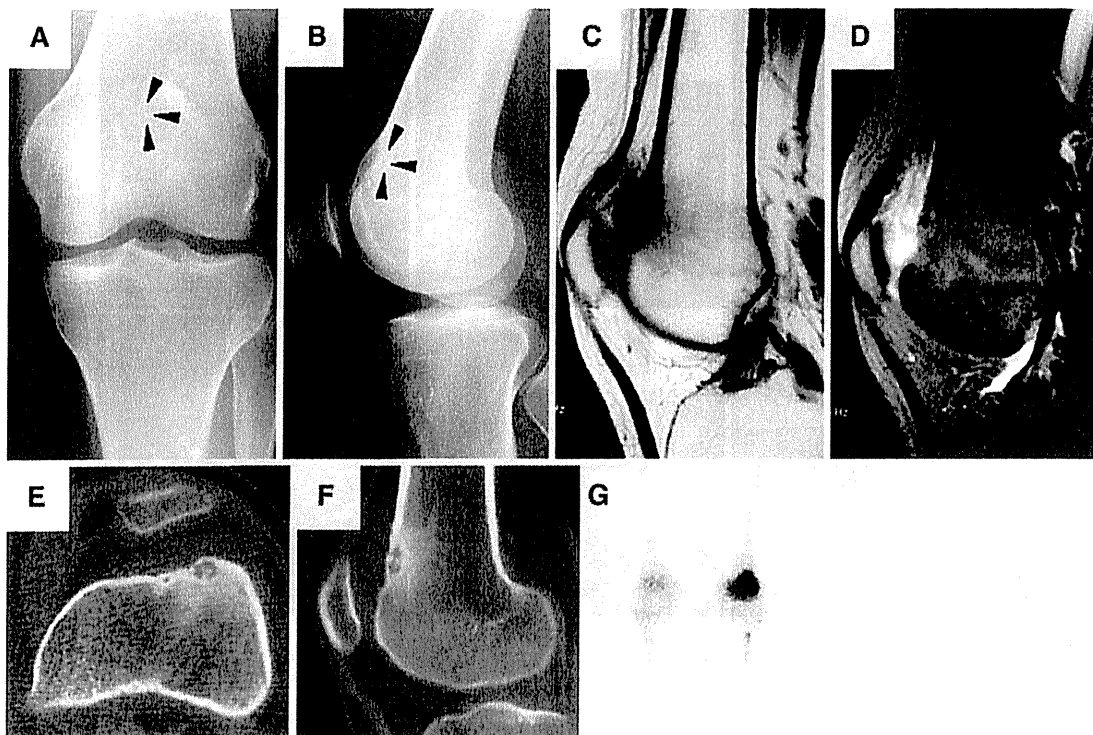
X-rays of the distal femur (a, b arrowheads). T1 (c) and T2 (d) weighted MRI images. e, f CT images revealed the nidus in the lateral condyle. g Technetium bone scintigraphy
